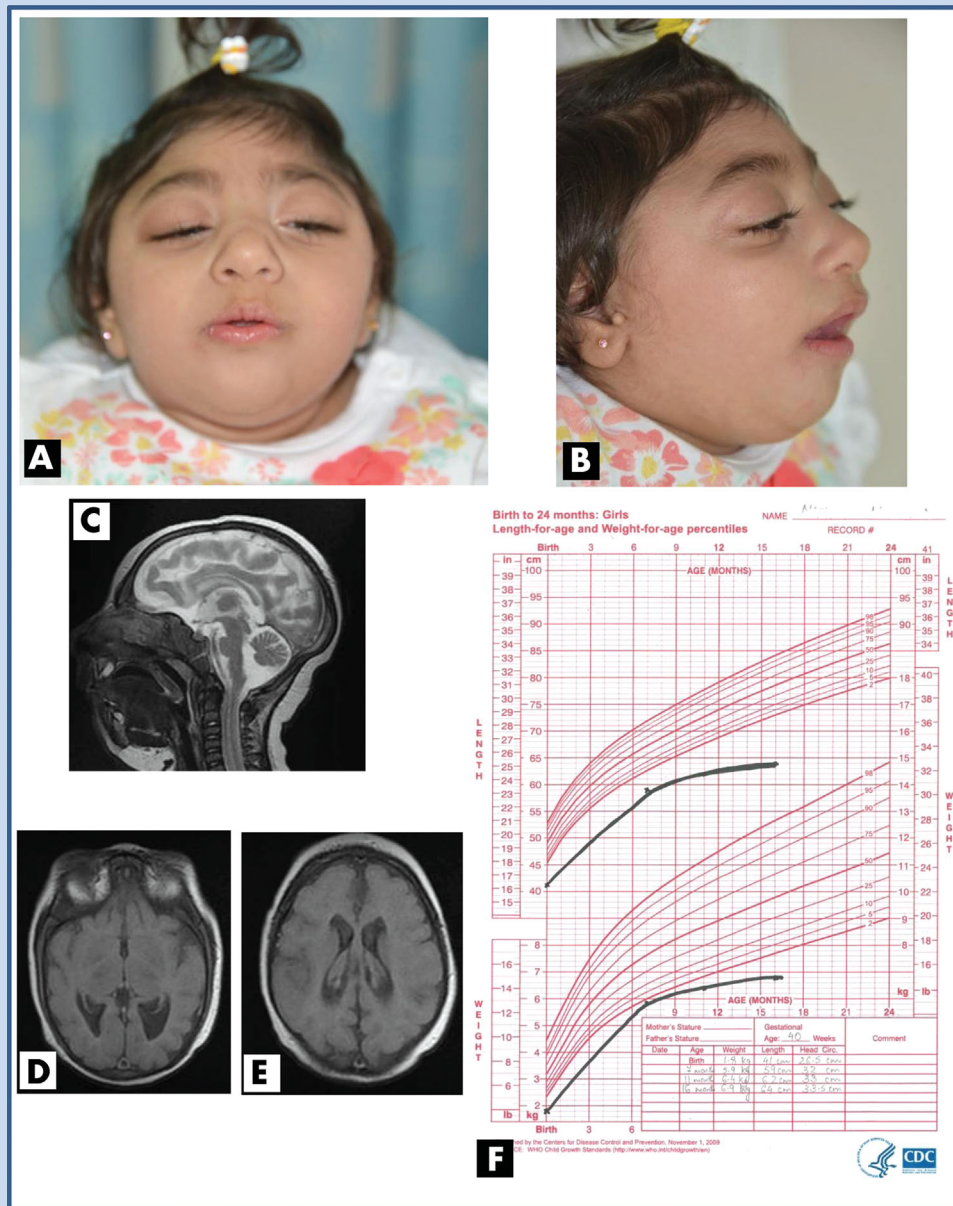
(A) and (B) Overview of dysmorphic facial features. The patient shows the presence of a sloping forehead, short nose with a depressed nasal bridge, short neck, and preauricular tags. MRI brain of patient show prominent cortical sulci and widened sylvian fissures, basal cisterns, and extra-axial CSF spaces, (C) is a T2 weighted sagittal view, (D) and (E) are T2 weighted coronal views. (F) Patient's body weight and length plotted on percentile charts showing both parameters to be consistently below the 3rd centile. [Color figure can be seen in the online version of this article, available at <http://wileyonlinelibrary.com/journal/ajmga>].
